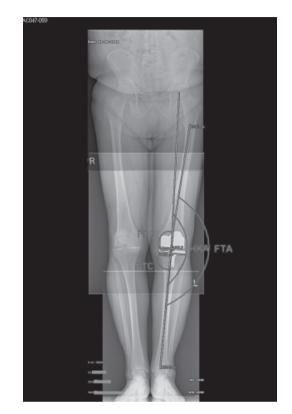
Radiograph showing the measured angles in the coronal plane. Depicting the angle between the femoral and mechanical axis (the hip knee angle [HKA]), the angle between the anatomical femoral and tibial axis (the femoral tibial angle [FTA]), the angle between the tangent to the most distal part of the femoral condyles and the mechanical axis (the frontal femoral component angle [FFC]), and the angle between the tangent to the mechanical axis (the frontal tibial component angle [FFC])
